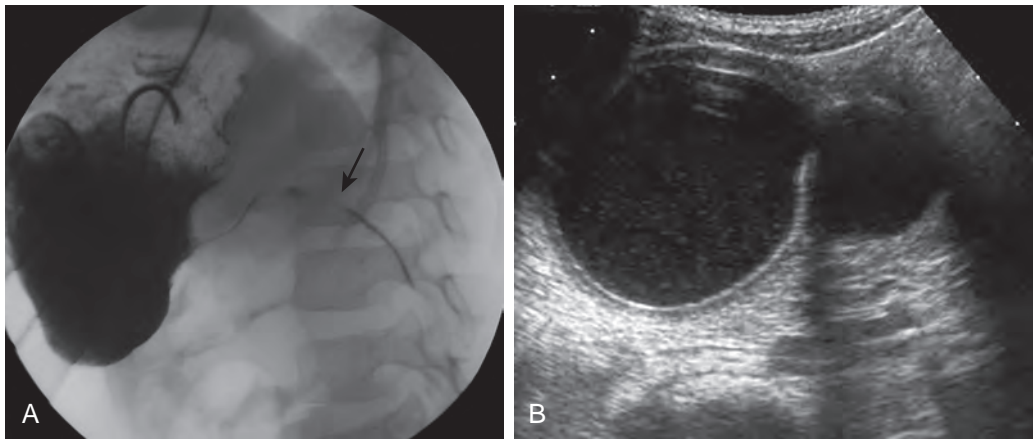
Gastric duplication cyst. A. Upper gastrointestinal examination in this 7-week-old infant with persistent vomiting shows extrinsic compression and mass effect on the gastric antrum and severe luminal narrowing of the proximal duodenum (arrow) with nearly complete obstruction. B. Corresponding sonogram confirms that the mass effect is caused by a large, bilobed cyst containing low-level internal echoes. The cyst wall exhibits the characteristic alternating hypoechoic and hyperechoic layers of bowel wall.
